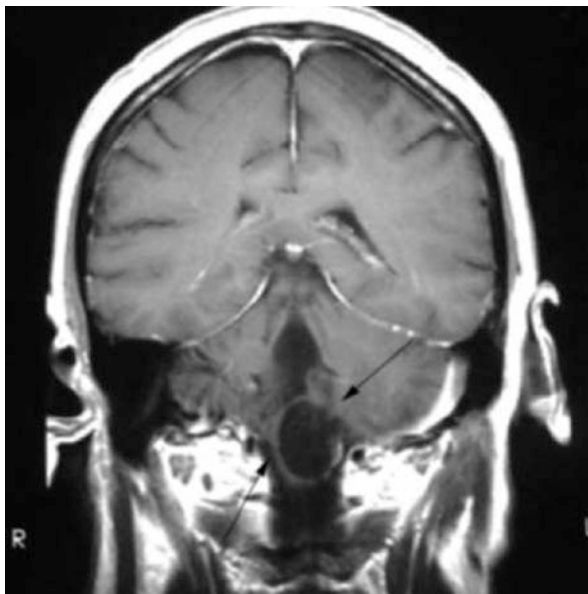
MRI disclosing cerebellar haemangioblastoma in von Hippel-Lindau syndrome; left, T2-weighted axial view of a paramedian cerebellar tumour; right, coronal section showing a cystic irregular rim-enhancing mass (with kind permission from Saara Metso [21])
